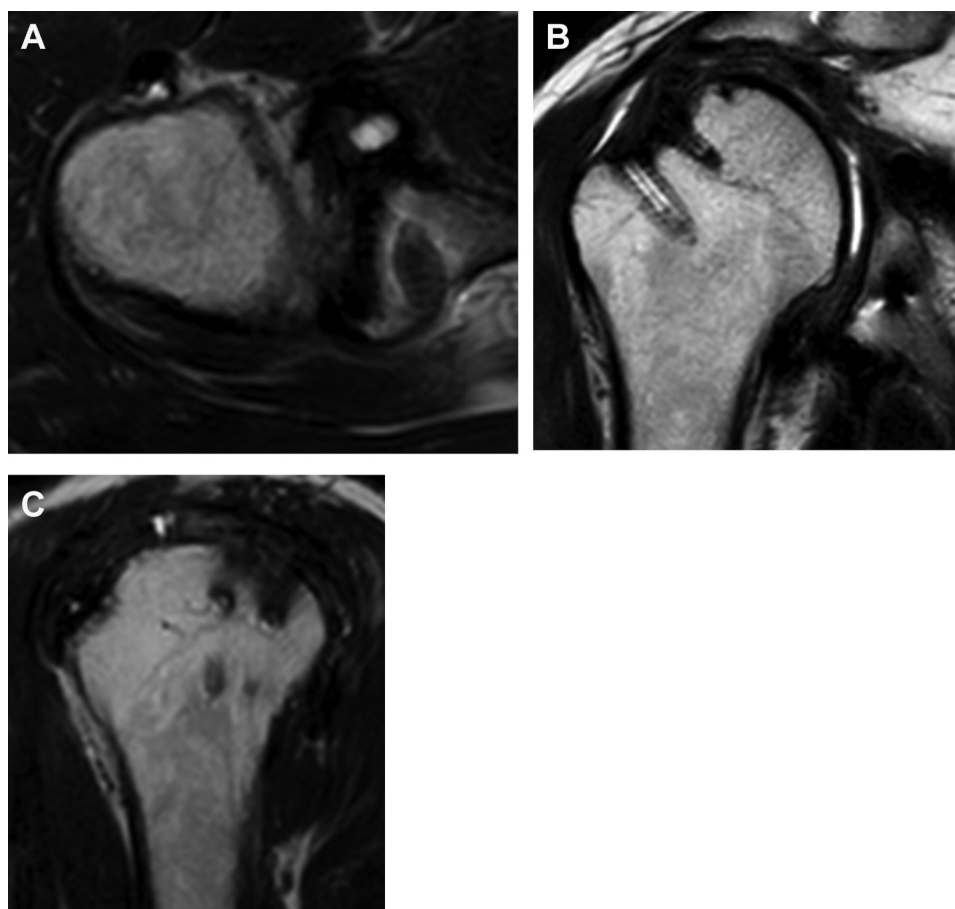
Magnetic resonance imaging at 24 months postoperatively. (A) Axial view. (B) Oblique coronal view. (C) Oblique sagittal view.
